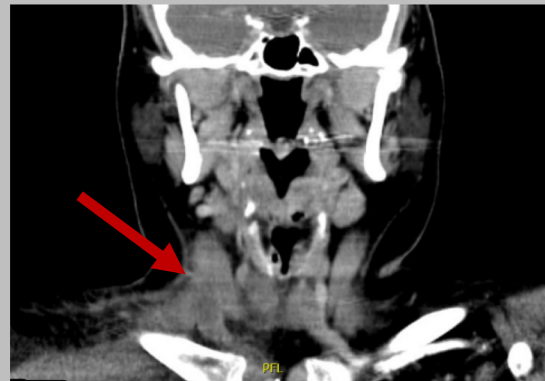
CT Neck with Contrast: Superimposed intramuscular abscess involving the distal right sternocleidomastoid muscle.
